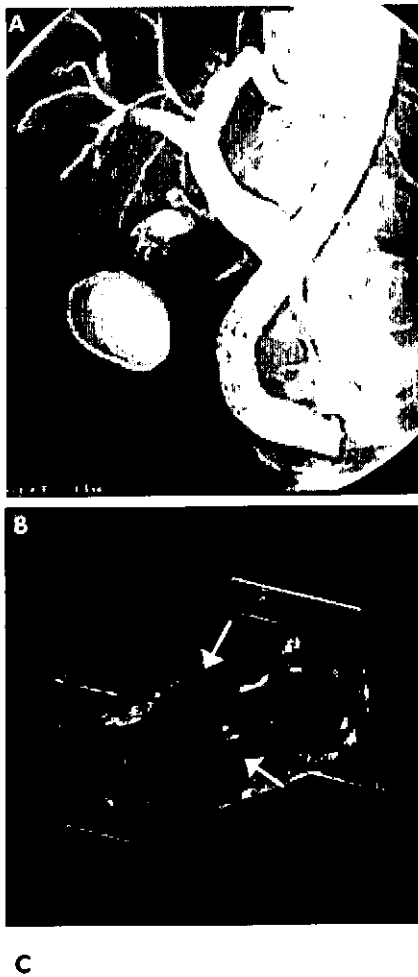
Distal periampullary cancer infiltrating the distal common bile duct (CBD). (A) Endoscopic retrograde cholangiopancreatography image with a 3 cm distal tumour stricture (arrow) and the miniprobe being introduced. (B) Three dimensional reconstruction of the miniprobe picture showing the proximal tumour end (arrows); the full tumour delineation in relation to the pancreatic head is seen on the conventional endoscopic ultrasonography image in (C); the arrows delineate the wall thickening extending from the area of the papilla/duodenal wall up to the CBD.
